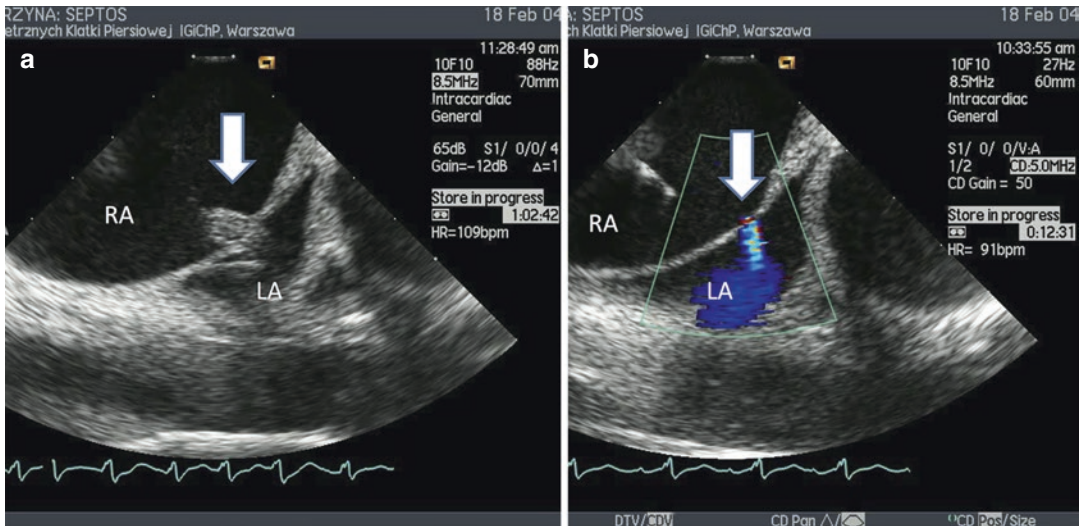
Intracardiac echocardiographic monitoring of (a) balloon inflation (*arrow*) and (b) right-to-left shunt after puncturing interatrial septum. RA right atrium, LA
